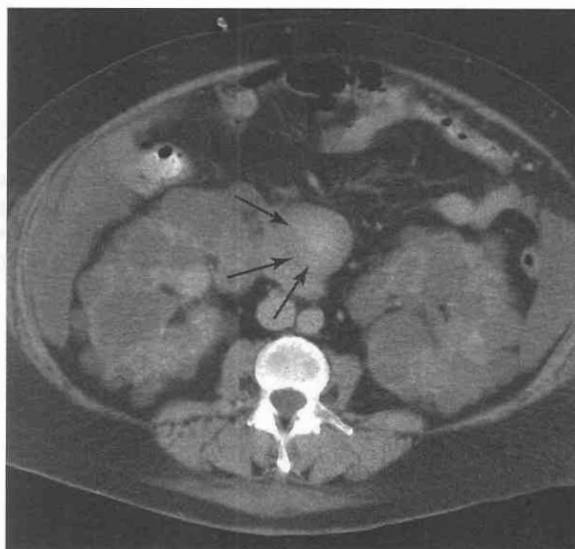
CT scan in a patient with polycystic disease of the kidneys shows massively enlarged kidneys with many cysts. Blood density mass is seen in the head of the pancreas, representing hemorrhage into a small pseudocyst (*arrows*).
